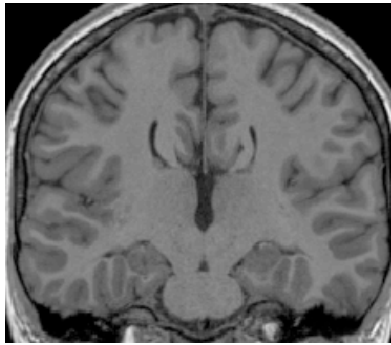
Coronal T1-weighted MRI presenting complete AgCC. The lateral ventricles form a bull's-horn appearance and are indented medially by the Probst bundles (arrows). Image taken from the AgCC Study of the Murdoch Children's Research Institute.
